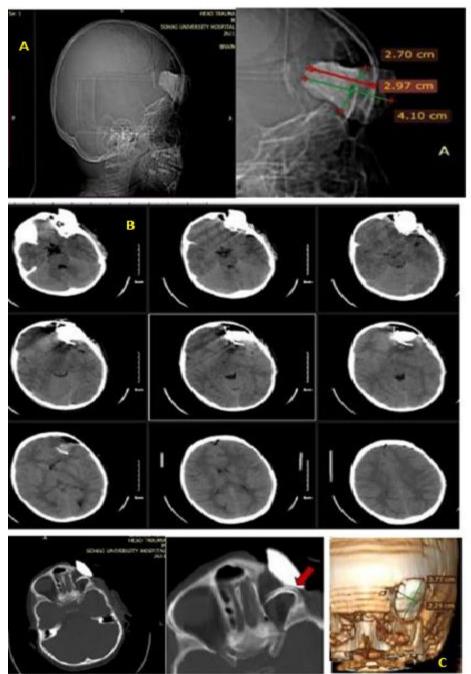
CT scan images (A-Scout, B-axial scans and C-3D reformatted image) a case of male patient 9 years old, fell from height and presented with a stone penetrated the skull – The case is published by the corresponding author and Abdelbary as a case report ⁽²⁾.
